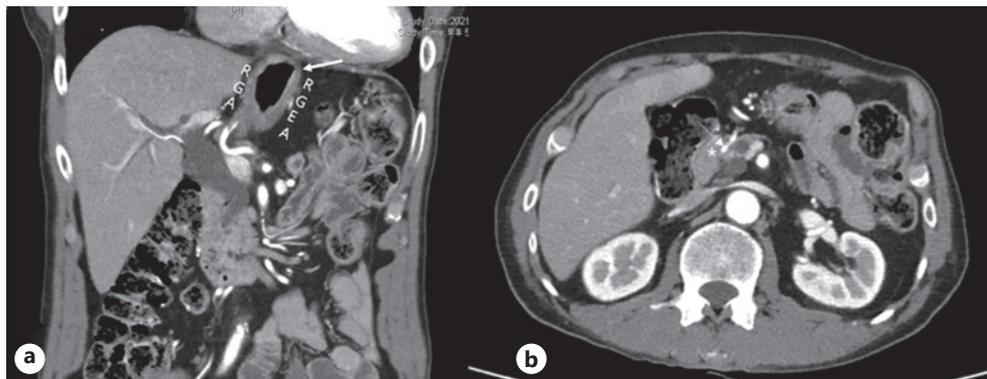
Preoperative CT scan. a Status of transhiatal esophagectomy. b Tumor abutting the gastroduodenal artery (yellow star: tumor; yellow arrow: GDA). CT, computed tomography; RGA, right gastric artery; RGEA, right gastroepiploic artery; GDA, gastroduodenal artery.
